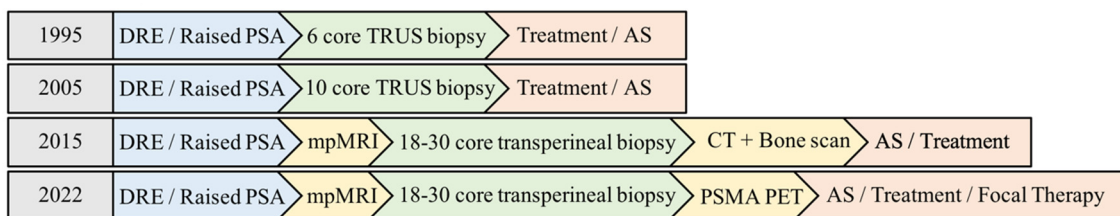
Change in the diagnostic pathway of prostate cancer over time. Abbreviations: Digital rectal exam (DRE), prostate-specific antigen (PSA), transrectal ultrasound (TRUS), active surveillance (AS), multiparametric magnetic resonance imaging (MRI), computed tomography (CT), prostate-specific membrane antigen positron emission tomography (PSMA PET).
